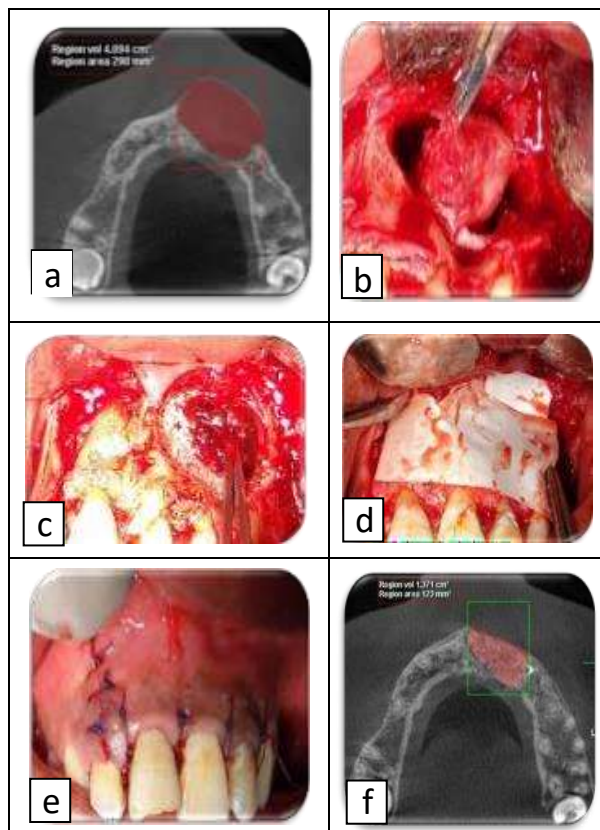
(a) Preoperative CBCT radiograph showing volumetric analysis on axial view of the segmented lesion, (b, c, d, e) Clinical intraoral photographs showing; the cyst lining separated from the surrounding bone, the bony defect filled with a mixture of fibrin glue and bone graft (sticky bone) and BMAC, adaptation of collagen membrane covering the grafting mixture, surgical flap repositioned and sutured, (f) Six months postoperative radiographs showing volumetric analysis on axial view of the segmented lesion.
